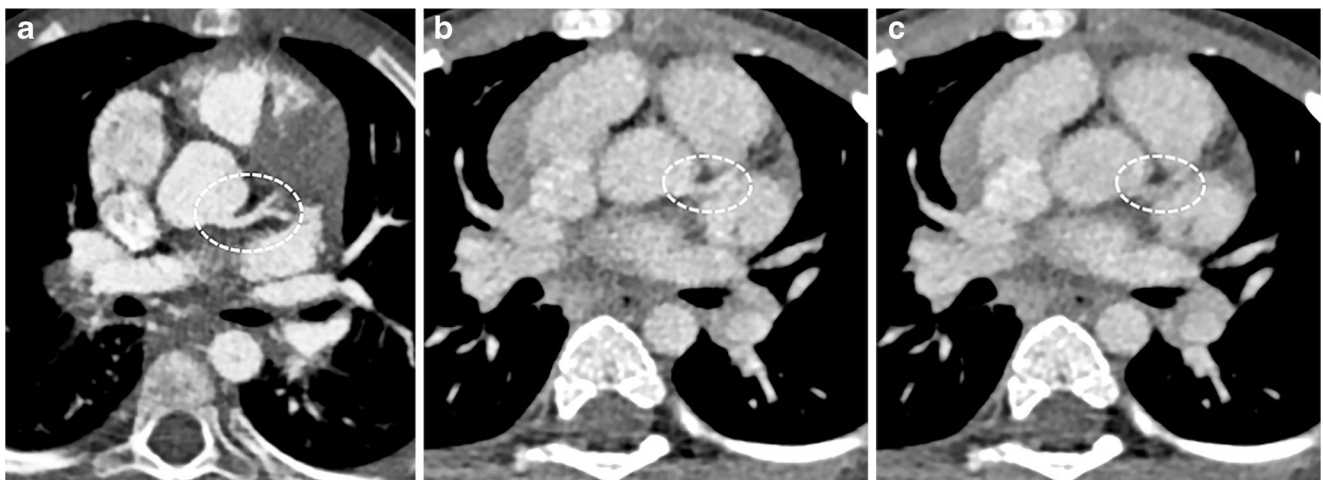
Comparison of the image quality of grades 3, 4 and 5, all levels at which a coronary segment was detected, on CT angiographic images. Grades 1 and 2 are not shown; in these the coronary segment was poorly visualized. a Grade 5. There is clear delineation of the left main coronary artery (*dashed circle*) without any motion artifact. This grade provides excellent diagnostic confidence. b Grade 4. There is clear
